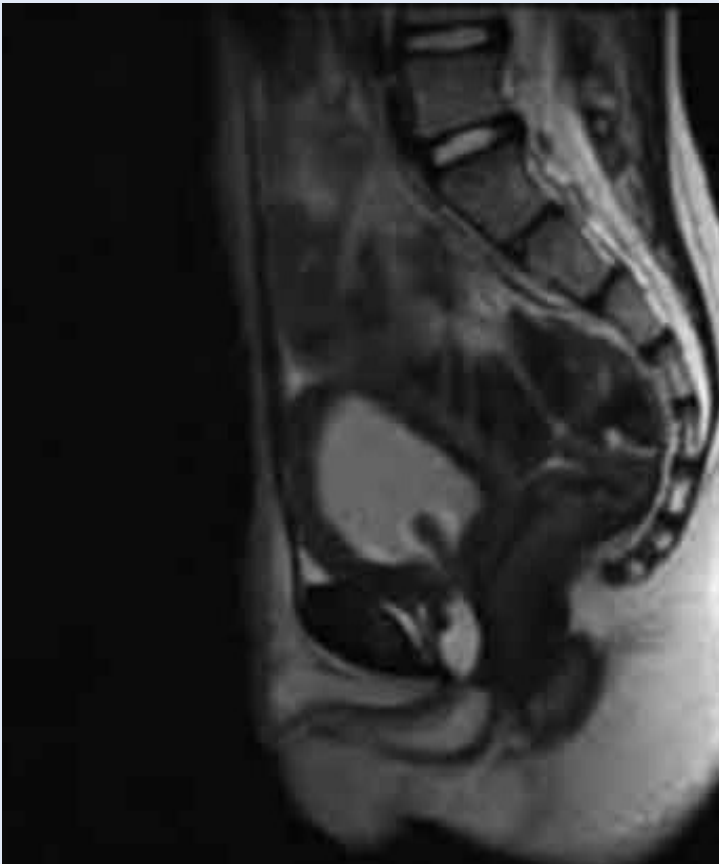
MRI showing the well-circumscribed polypoid lesion (2x1 cm) with low signal intensity, arising from the posterior urethra, passing through the bladder neck and entering the bladder inner space.
